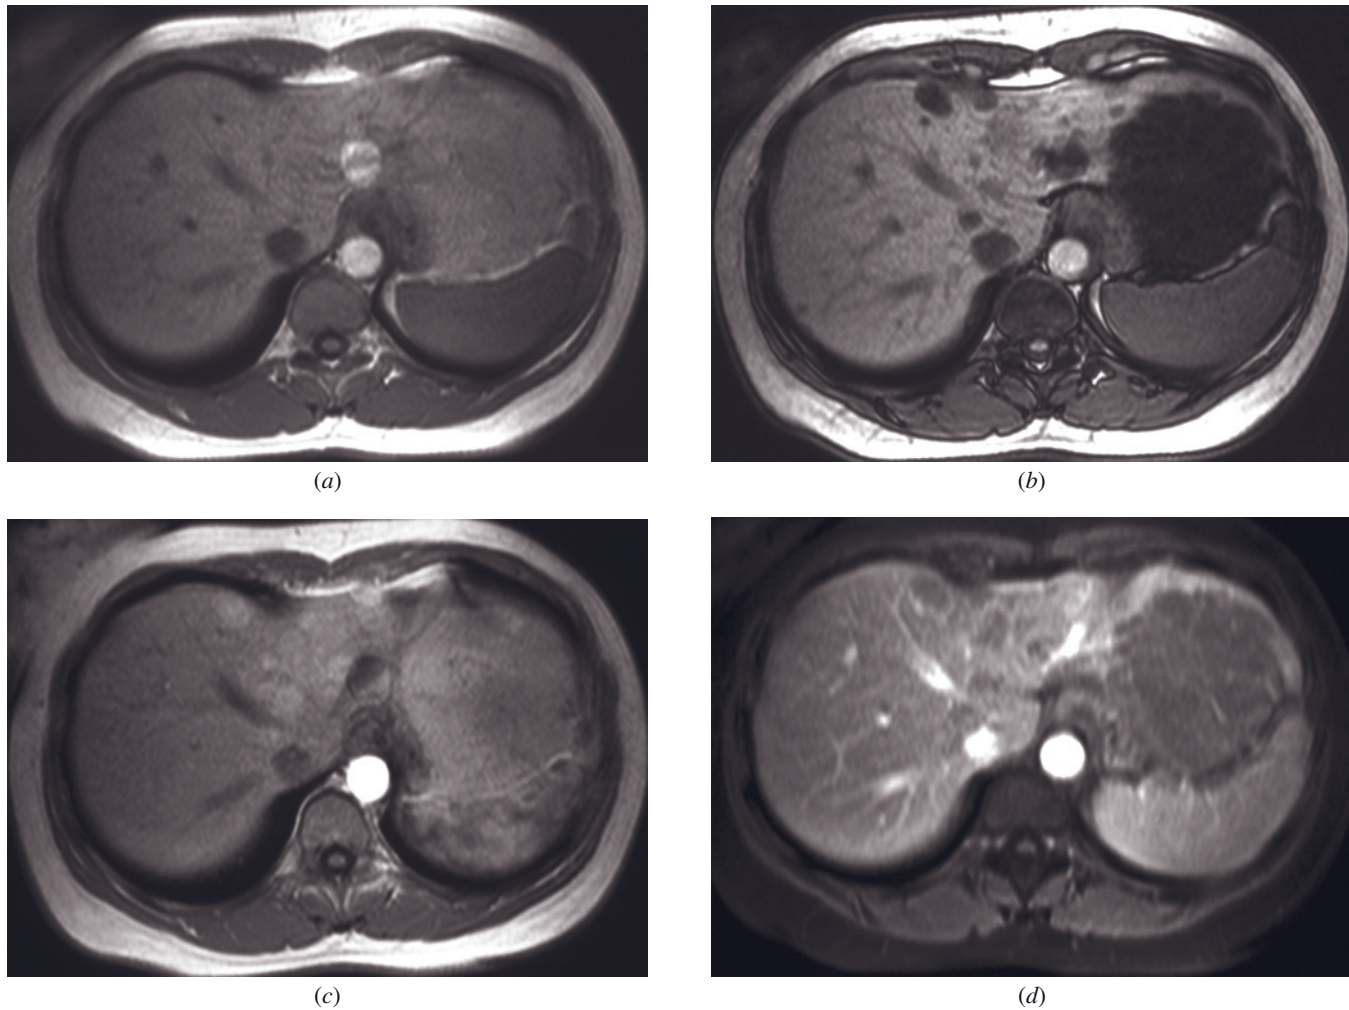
Fat containing adenomatosis. SGE (a), out-of-phase SGE (b), and immediate (c) and 90-s fat-suppressed (d) post-gadolinium SGE images. Multiple lesions with varying sizes are seen predominantly present in the left hepatic lobe that show isointensity on T1-weighted images (a) and drop in signal intensity on out-of-phase images (b) and show a faint homogeneous enhancement on early-phase images (c) compatible with fat-containing adenomatosis. On the late-phase image (d) some lesions show lower signal intensity than background parenchyma, which may reflect a fat suppression effect, lesion washout, or a combination of both.
